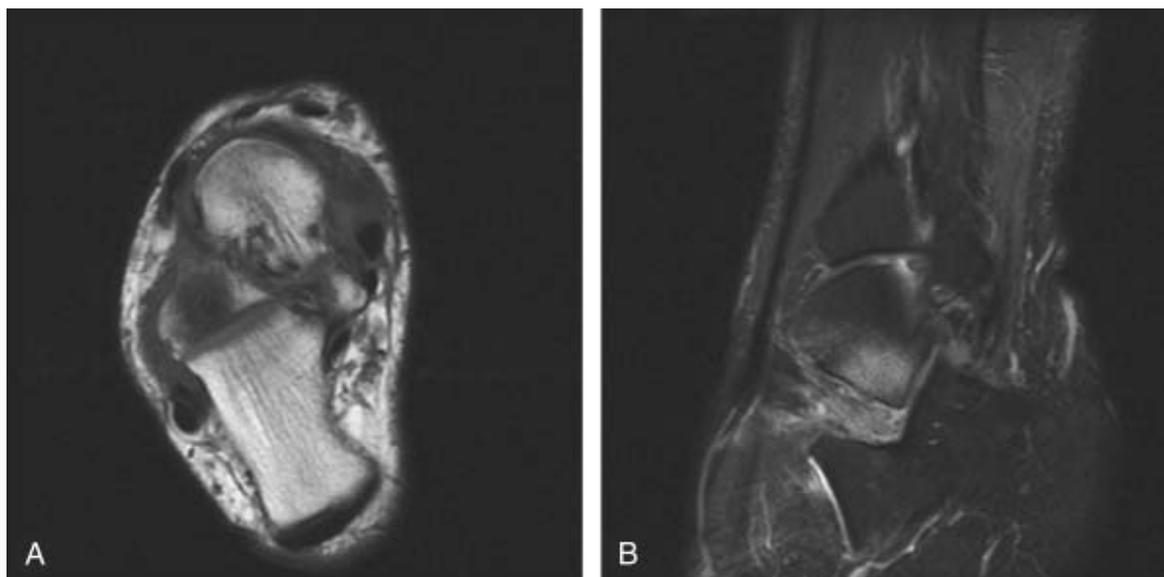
9 This athlete underwent magnetic resonance imaging for persistent lateral hindfoot pain. T1-weighted (A) and T2-weighted (B) sequences demonstrate the marrow edema indicative of a nondisplaced stress fracture of the lateral process. (Courtesy of James W. Brodsky, MD.)
